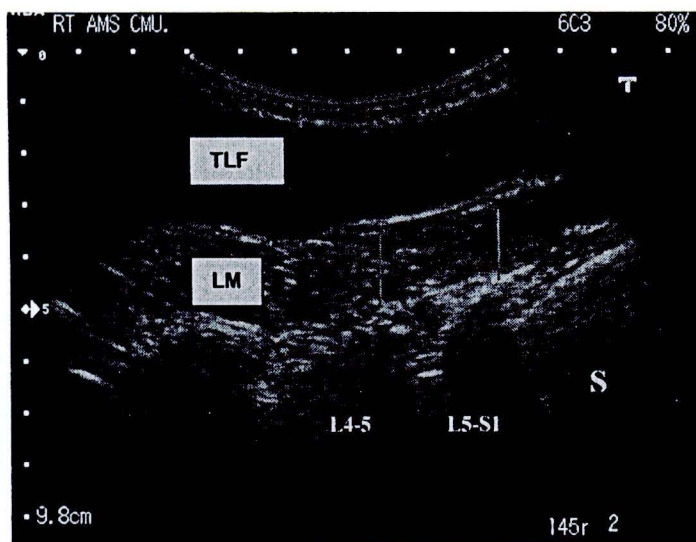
Ultrasound image of right lumbar multifidus (LM) muscle in longitudinal section. Sacrum (S) and thoracolumbar fascia (TLF) were identified in the image. LM muscles thickness were measured from the tip of L4-5 and L5-S1 zygapophyseal joint to the inside edge of the superior border of LM.
